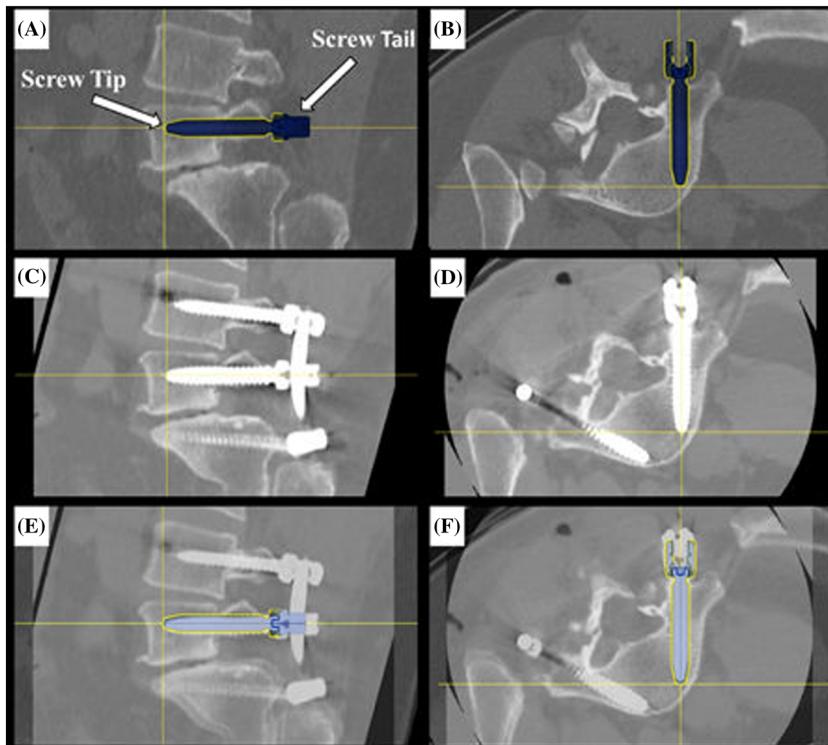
Screw tip, tail, and angle offset assessment. Right L5 screw planning: A, sagittal; B, axial planes. Image overlay analysis with preoperative planned trajectory and postoperative screw placement: C, sagittal planes; D, axial planes. Postoperative CT of L5 screw placement without a medial or lateral breach: E, sagittal plane; F, axial plane. The crosshairs indicate screw tip. CT, computerized tomography
